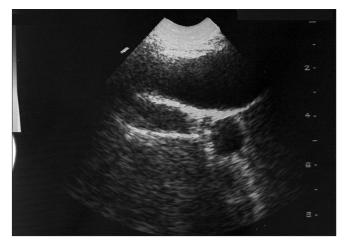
Ultrasound with probe placed at lateral aspect of right hypochondrium
